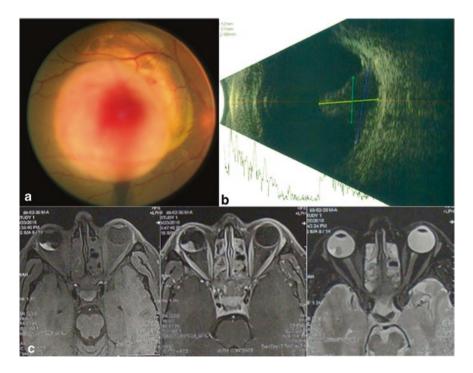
a Fundus photo of a 60 years old male, shows a big posterior pole mushroom shaped mass with both melanotic and amelanotic portions of the tumor. Fresh hemorrhage probably due to Bruch's membrane rupture, limited to the top of the lesion is present. b B-scan revealed the mushroom shape of the lesion. c MRI revealed no extraocular extension. Unlike the usual T2 appearance of the choroidal melanoma, in this patient, the lesion is more reflective than vitreous (due to intra-lesion hemorrhage or edema)
